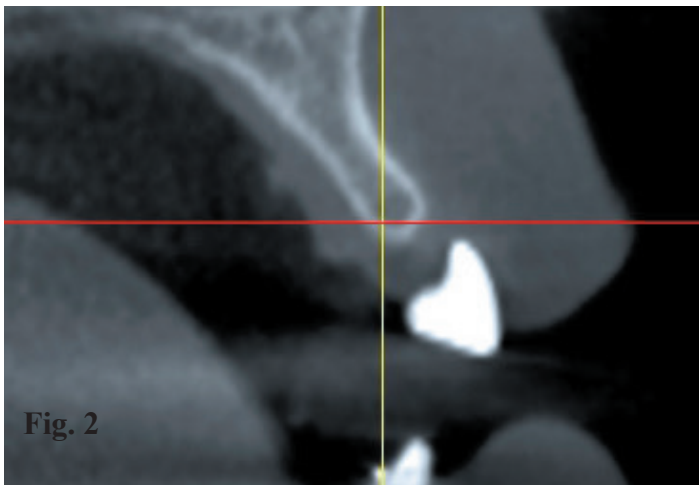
A CBCT scan confirms the thickness of the bone in the buccal-lingual dimension is inadequate for placement of a dental implant. Figure 3. Following ridge augmentation, a follow-up CBCT scan shows the bone is now sufficient for placement of an implant.
